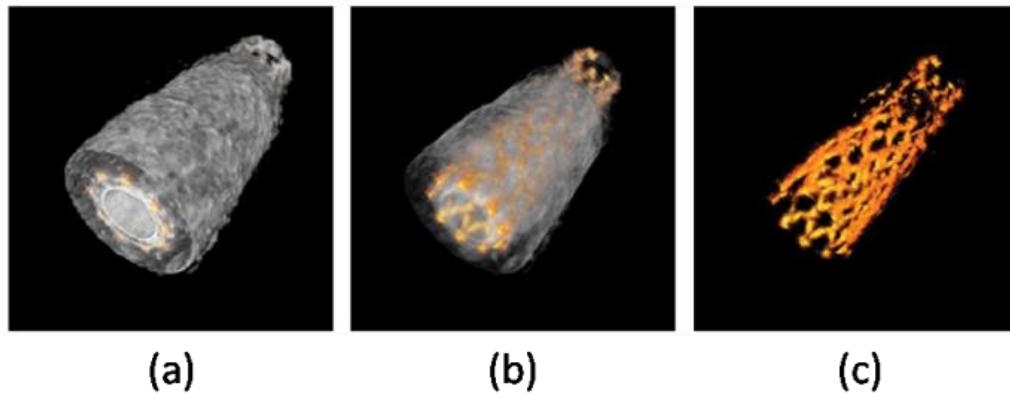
Three-dimensional (3D) reconstruction of the vessel and stent. The 3D image was created by acquiring a stack of cross-sectional images and combining them together. The ultrasound and photoacoustic signals can be displayed with different transparency in the reconstructed image to show the position and shape of the stent within the vessel.
